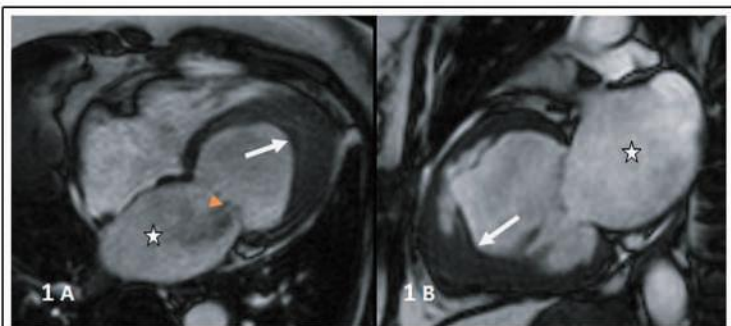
A and B : Cardiac MRI still image of cine Steady-State Free Precision(SSFP)MRI sequence in 4-chamber and 2 chamber shows LV apical thickening with apical obliteration (white Arrow), Mild left atrial enlargement (*) and Moderate MR (orange arrow head).
